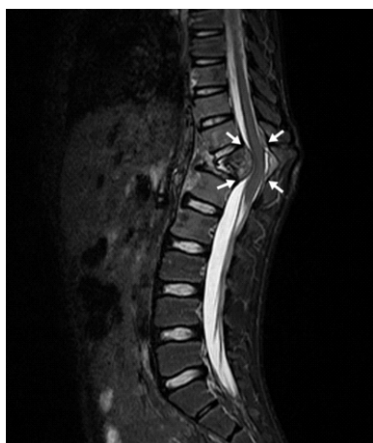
A 10 years old boy with spine TB. Sagittal T2-weighted MRI images showed epidural and paravertebral abscess formation, and spinal cord compression (arrow).
